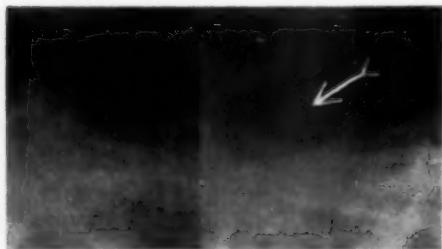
(Hedges and Cardoso de Melo). Calcification of the lens seen by X-ray examination of the right orbit, using the Sweet method.
